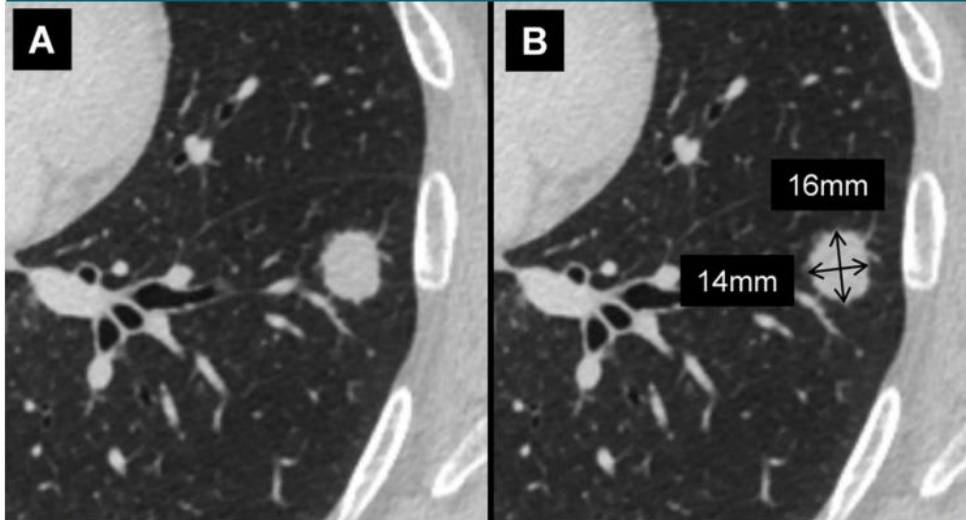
Transverse CT sections of a solid nodule in the left lower lobe. *A*, The nodule is anatomically well defined. *B*, First, the maximal long-axis diameter is measured (16 mm, vertical arrow). Then, perpendicular to the long-axis measurement, the maximum short-axis diameter is measured (14 mm, horizontal arrow). The average diameter of the nodule is 15 mm. As detailed in the first recommendation, for purposes of risk estimation, the dimension of small pulmonary nodules (<10 mm) should be expressed as the average of maximal long-axis and perpendicular maximal short-axis measurements in the same plane. For larger nodules and masses (≥ 10 mm), long- and short-axis measurements should be recorded. Because the average diameter of this nodule is larger than 10 mm, both long- and short-axis measurements are given.
